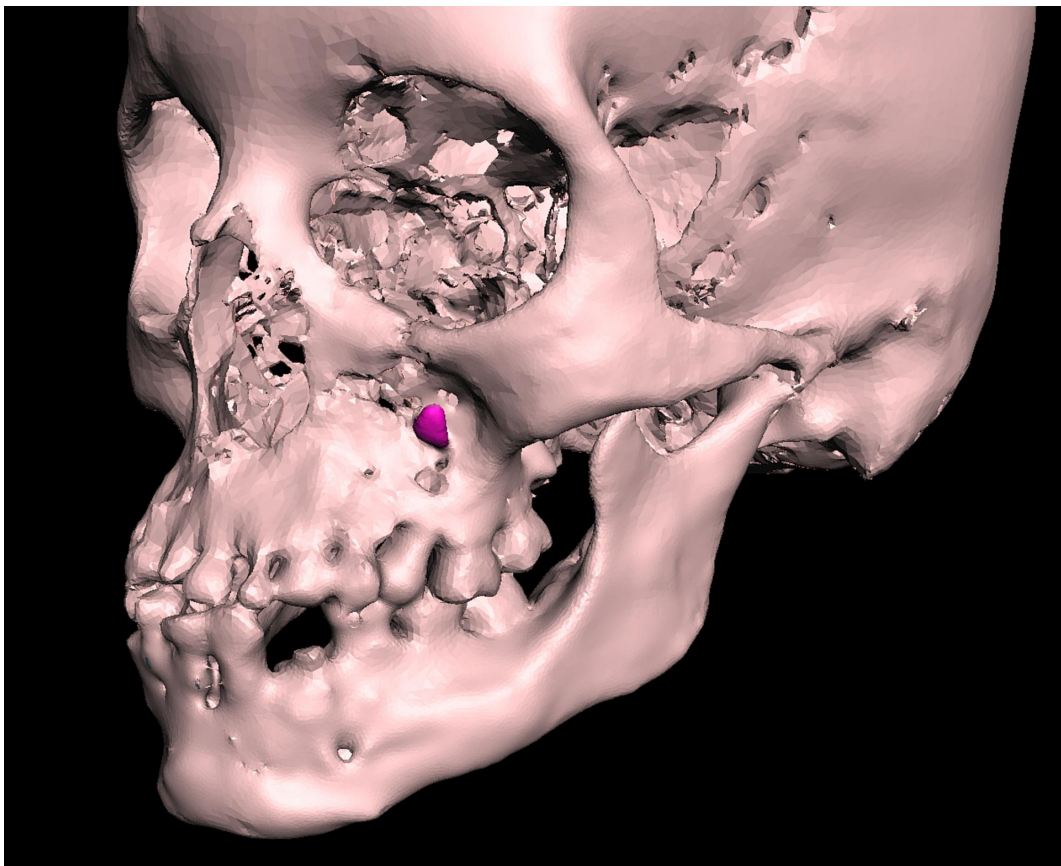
3D CT scan of maxilla and mandible showing presence of an ectopic tooth (*in lilac colour*) overlying the anterior surface of the left maxillary bone. This is an extremely rare location to find ectopic tooth.
